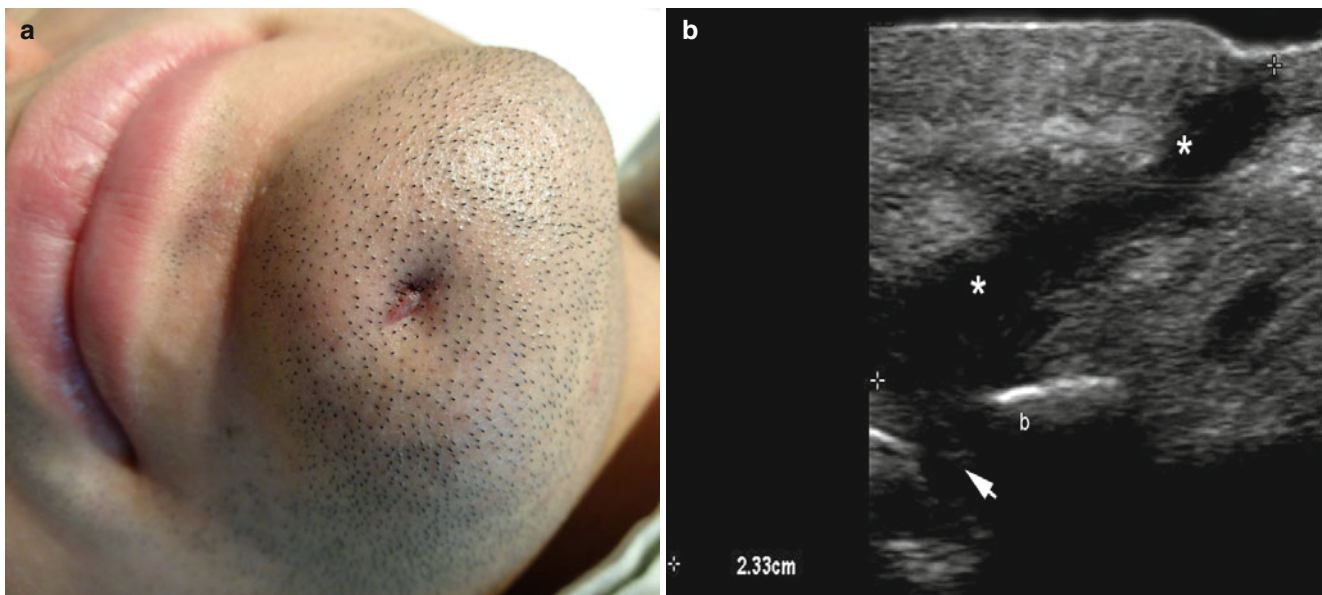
(a, b) Odontogenic fistula. (a) Clinical image shows a depressed erythematous scar-like lesion in the right aspect of the chin. (b) Grey scale ultrasound image (longitudinal view) demonstrates a
